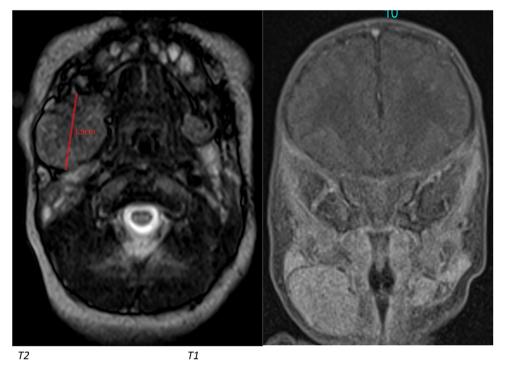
Magnetic resonance imaging (MRI) neck. Well-defined soft tissue mass in right submandibular region.
